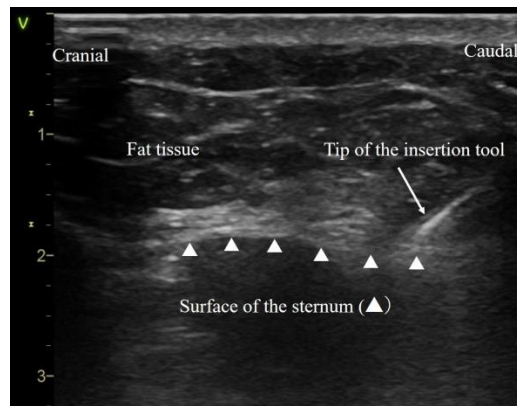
Demonstration of subcutaneous structure such as sparse fat tissue, curved surface of sternum, and sternocostal joints by transthoracic echo.
